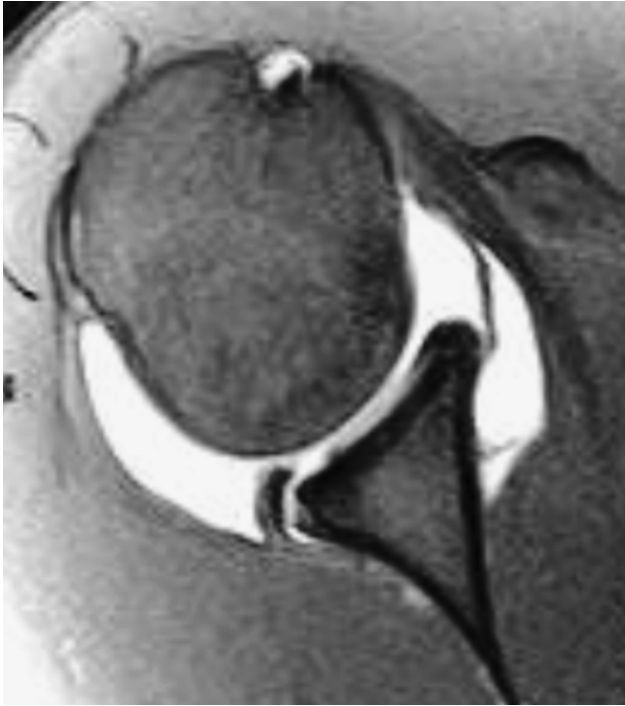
Magnetic resonance image of a patient with a posterior inferior labral tear. Imaging findings did not always clearly demonstrate the extent of the pathology.
